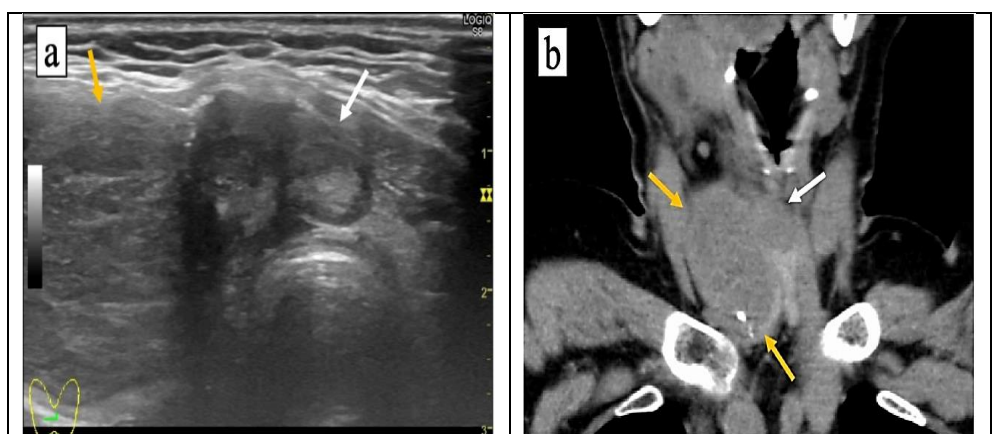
(a): representative ultrasound imager. The right thyroid glands lobe has a well-marked mass lesion (yellow arrow), and the isthmus has an unclear mass lesion (white arrow). 1(b): A representative CT scan picture. The mass lesion in the isthmus (white arrow) and tumour of the right thyroid lobe (yellow arrow) are visible.
